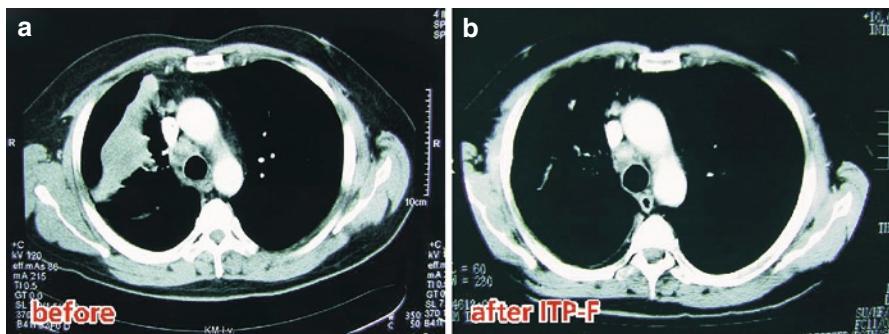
(a) CT scan before isolated thoracic perfusion with chemofiltration. (b) CT scan 4 weeks after isolated thoracic perfusion with chemofiltration
